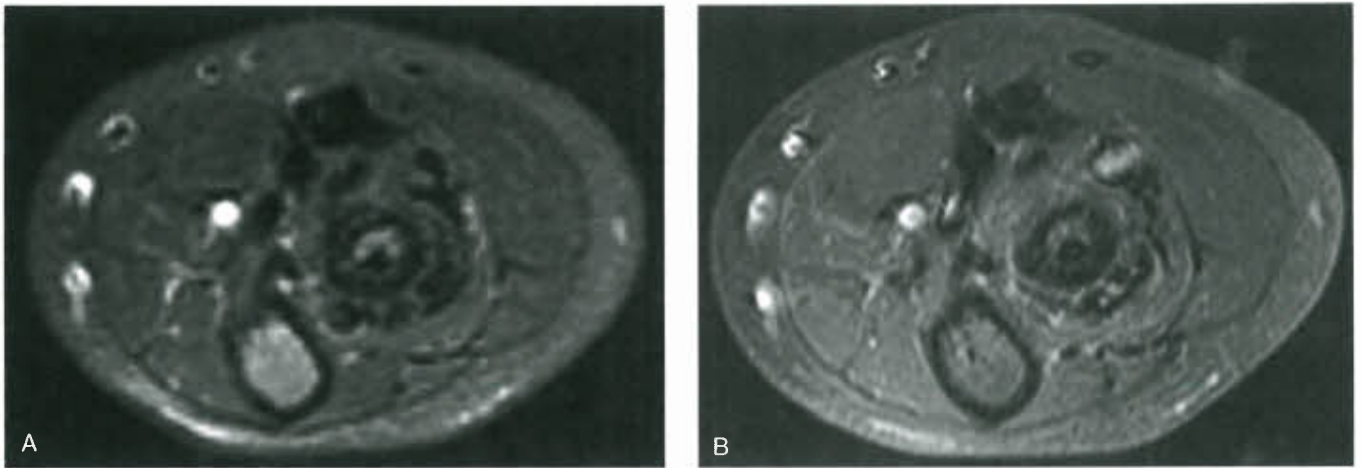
MRI of arteriovenous malformation. Axial T2 (A) and postcontrast T1 (B) MRI sequences show a tangle of flow voids (enlarged blood vessels) around the proximal aspect of the radius bone. Note lack of soft tissue mass.
